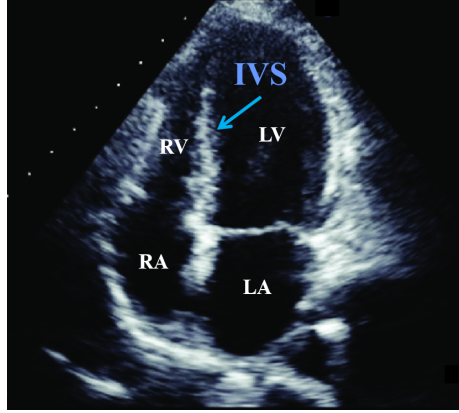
Echocardiographic visualization of the four-chamber apical view. RV: right ventricle; LV: left ventricle; RA: right atrium; LA: left atrium; IVS: inter-ventricular septum. Figure reproduced from [37].
